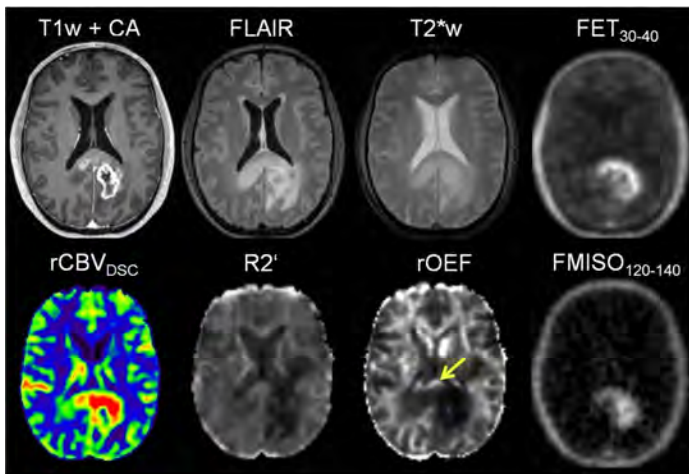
Selected slice of a male patient (56y) with GBM. Anatomical MRI (T1w with CA, FLAIR, T2*w), ¹⁸F-FET PET, rCBV, R2', rOEF, and ¹⁸F-FMISO images. Please note that the border of the brain and ventricles appear bright in the rOEF map because of magnetic susceptibility artifacts and low rCBV.
